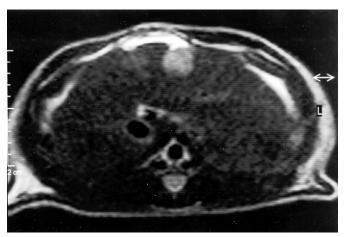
Magnetic resonance image of one induced liver tumor (tumor diameter approximately 5 mm) 3 wk after injection of DHD-K12 cells directly under the liver capsule.
